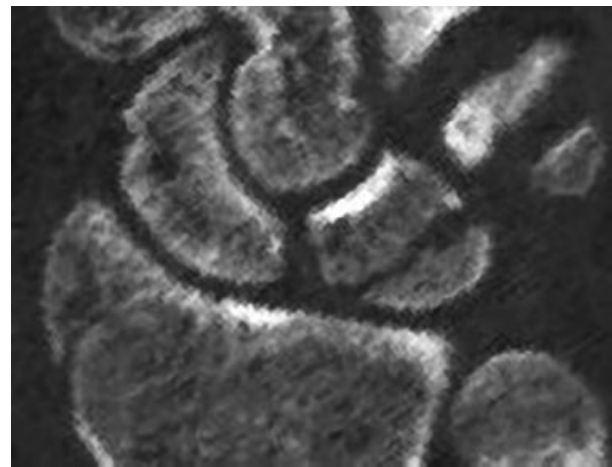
CT scan coronal slice focusing on the fracture lines shown in ►Fig. 1.
